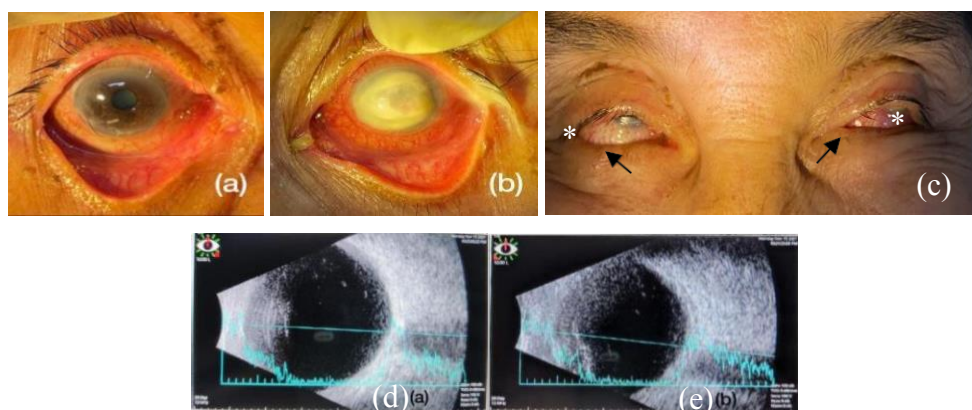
Anterior segment photographs and ultrasonography. (a) Conjunctival hyperemia of the right eye, (b) Severe corneal ulceration with epithelized micro perforation (c) Lagophthalmos (asterisk) and madarosis (black arrow), (d) and (e) normal ultrasonography of both eyes.
